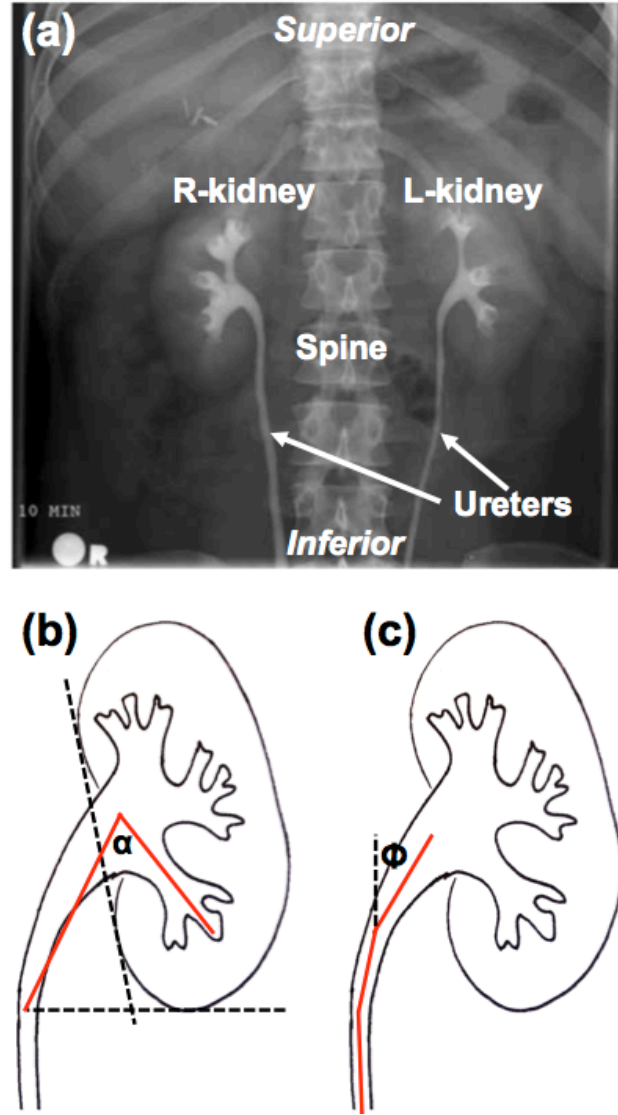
(a) Radiograph, with injected contrast agent, of the upper abdomen showing the urinary tract [115]. (b) Representative infundibulopelvic angle  $\alpha$  previously investigated. (c) A proposed angle of interest  $\phi$  for this study investigating the angle between the ureter axis and vertical axis of respiration varies along the location of the ureter.
